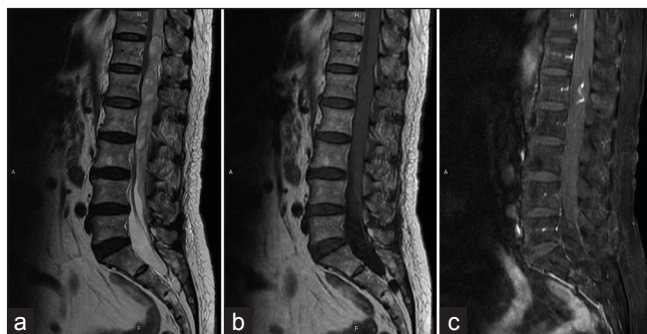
Magnetic resonance imaging of the lumbar spine. (a and b) Sagittal T2-weighted image and T1-weighted image revealed a heterogenous hyperintensity and isodensity posterior epidural mass extending from T9 to L4, respectively. (c) After injection of gadolinium, sagittal T1-weighted image revealed no enhancement
